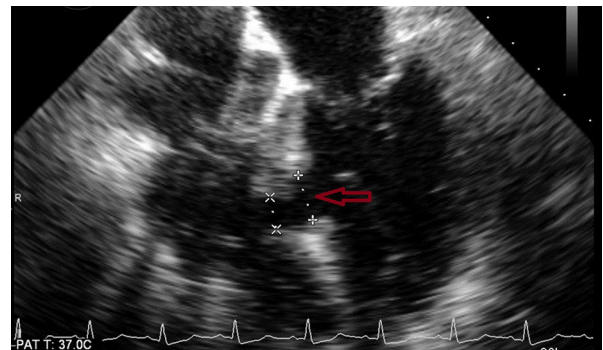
Transesophageal echocardiogram showing ventricular septal defect (arrow) with size.
